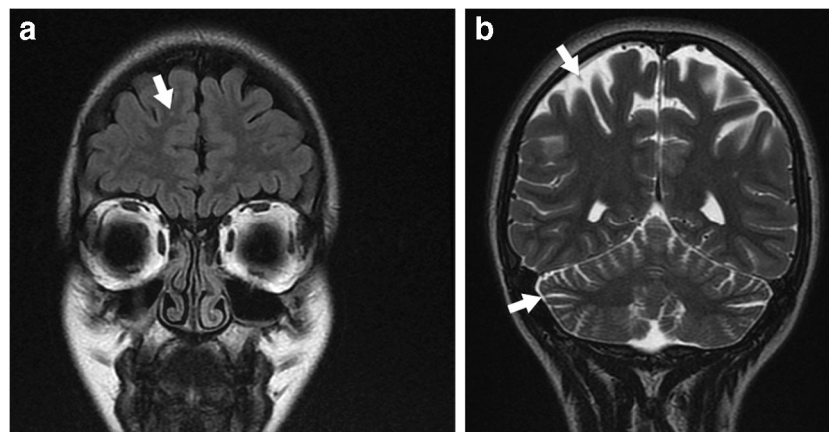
Hyperimmunoglobulin D syndrome in an 18-year-old girl who presented with headache and pyramidal signs. a Coronal fluid-attenuated inversion recovery (FLAIR) MRI of the brain shows a non-specific subcortical focus of high signal intensity (arrow), a finding that
